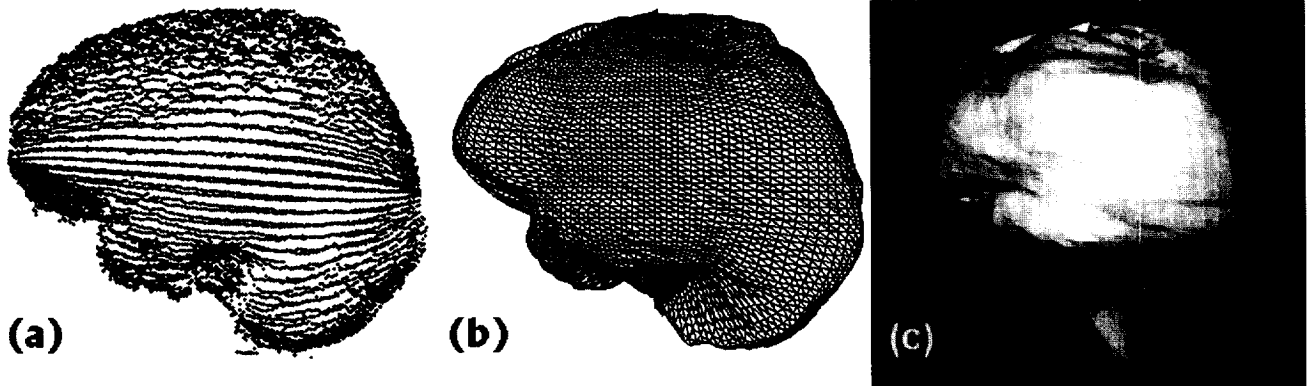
An example of generating a parametric surface for contour mapping. (a) The 'cloud' of surface points extracted from the MRI scans of the brain. (b) The resultant surface, composed of triangular elements. In (c) the surface is rendered using a light shading model.
